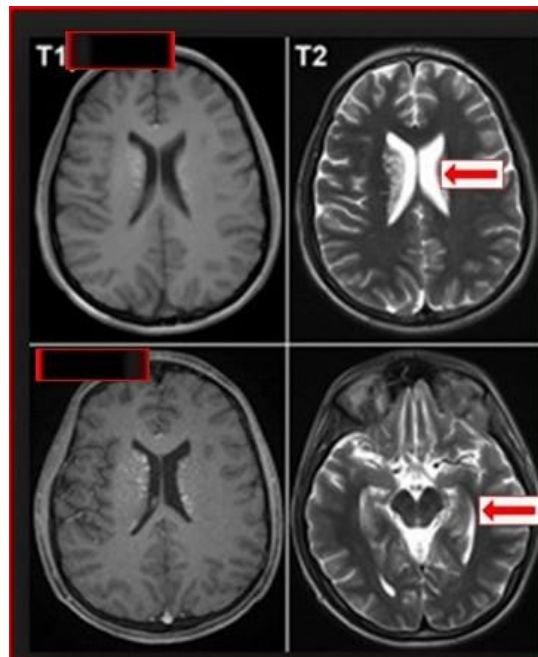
Brain MRI showed atrophy of the caudate.
